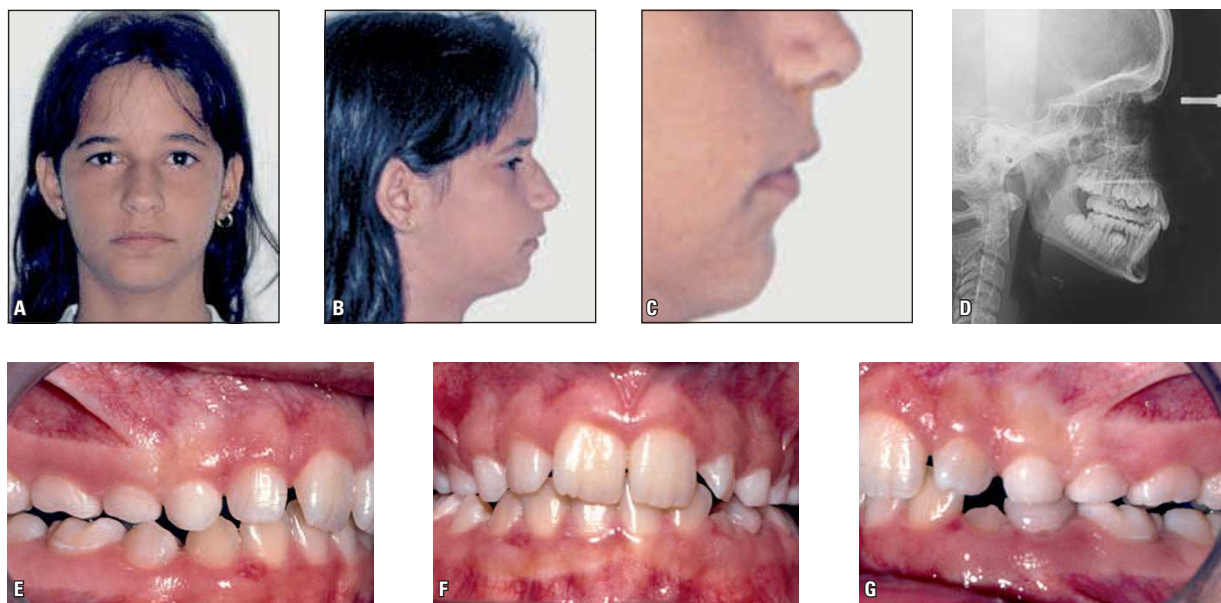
Extraoral photographs (A, B, and C), cephalometric radiograph (D) and intraoral photographs (E, F and G) at the end of the first treatment phase.
